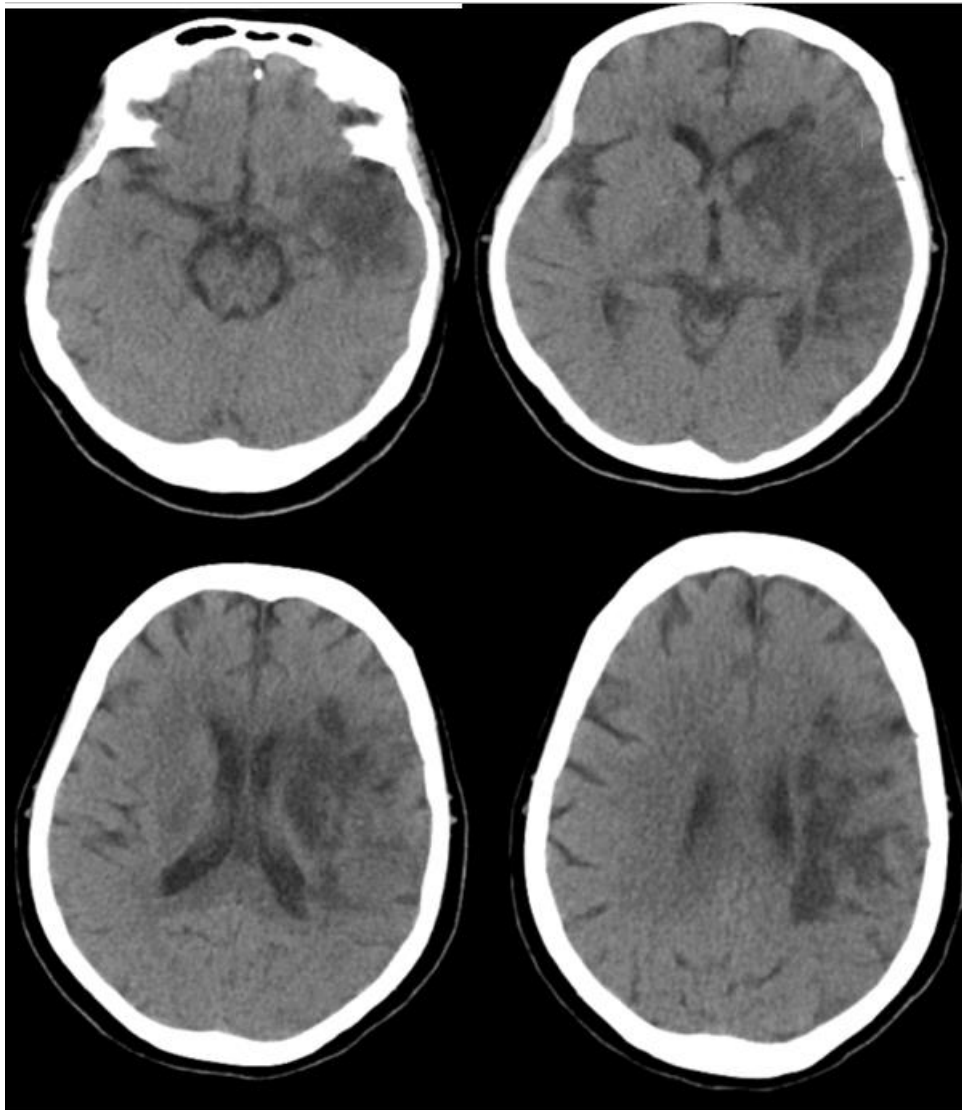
Brain CT scan showed a left temporal-parietal ischemic stroke with minimal midline shift.
